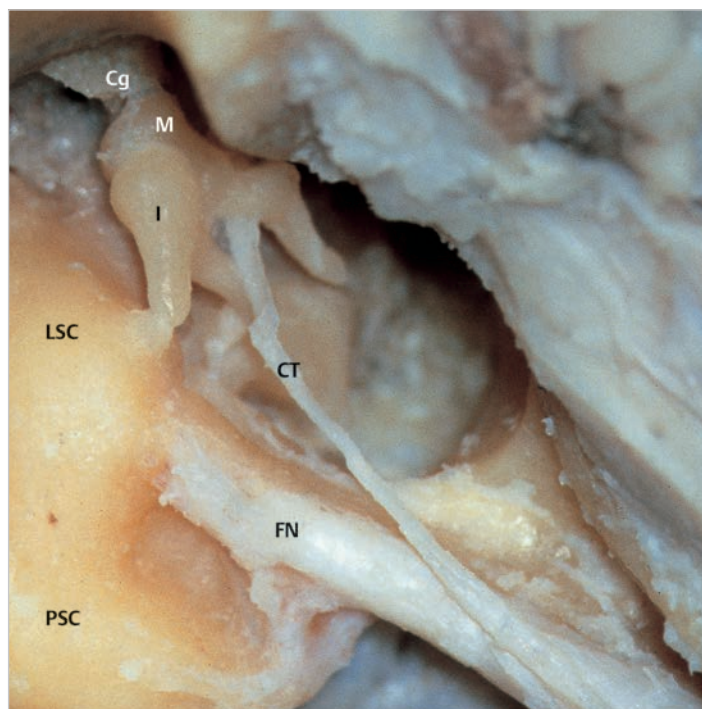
Posterior canal wall and the tympanic membrane are removed. Semicircular canals are skeletonized. The chorda tympani enters the tympanic cavity through the posterior wall, and runs laterally to the long process and medially to the neck of the malleus. Cg, cog; CT, chorda tympani; FN, facial nerve; I, incus; LSC, lateral semicircular canal; M, malleus; PSC, posterior semicircular canal.
